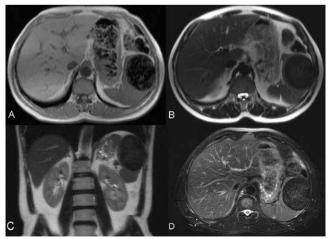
Magnetic resonance imaging demonstrating a sharply demarcated, hypointense mass in the spleen. The mass was predominantly hypointense on T1-weighted axial (A) and T2-weighted axial (B) and coronal (C) images. Fat saturated T2-weighted image revealed no fat content (D).
